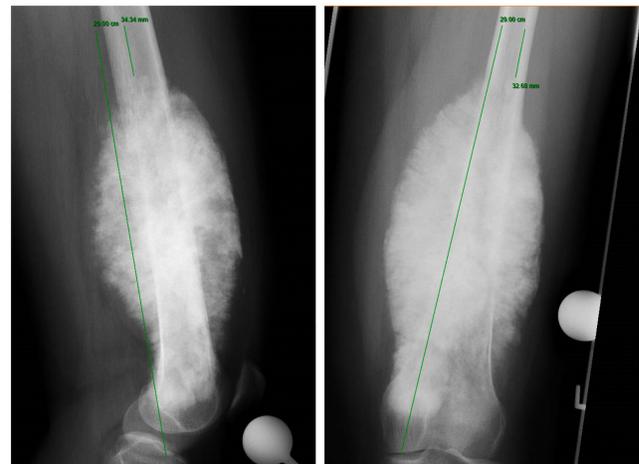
Representative electronic measurement method on X-ray. Plain film of a distal femur with osteosarcoma in a lateral view (left) and anterior-posterior view (right). The resected length of bone in this patient was 29.0 cm indicated by the longer green line in each panel.
